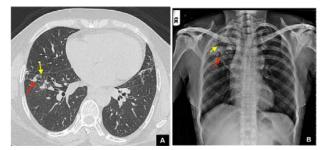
(A) Fibronodular changes (red arrow) are seen in right lower lobe with surrounding discrete nodules (yellow arrow), the activity of the nodules cannot be decided in absence of previous imaging. Clinical workup and follow up CT scan after 3 months is indicated in such cases. (B) Consolidation with internal cavitation is seen in right upper zone. There is widening of bilateral paratracheal strip (due to mediastinal lymphadenopathy). These findings are in favour of active tuberculosis.
